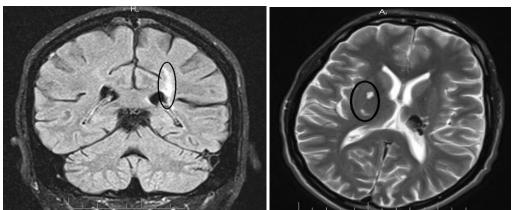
MRI excludes supratentorial polymorphic lesions, looking suggestive for a sequel with fluid type signal in axial and coronal slices. Other injuries occur hiperintense on T2 and FLAIR sequences
